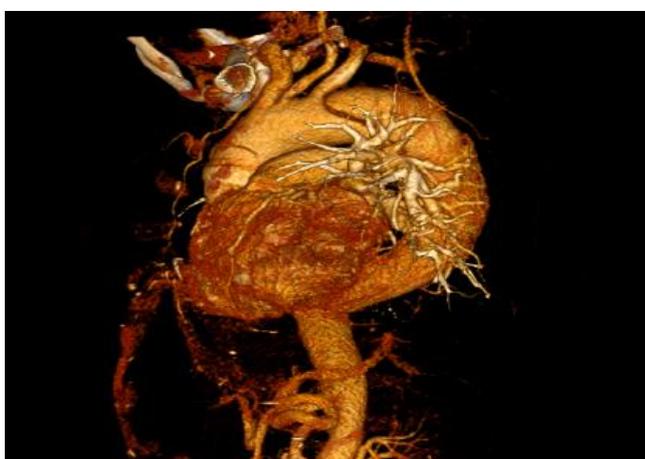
CT scan image showed dissecting flap in descending aorta.
